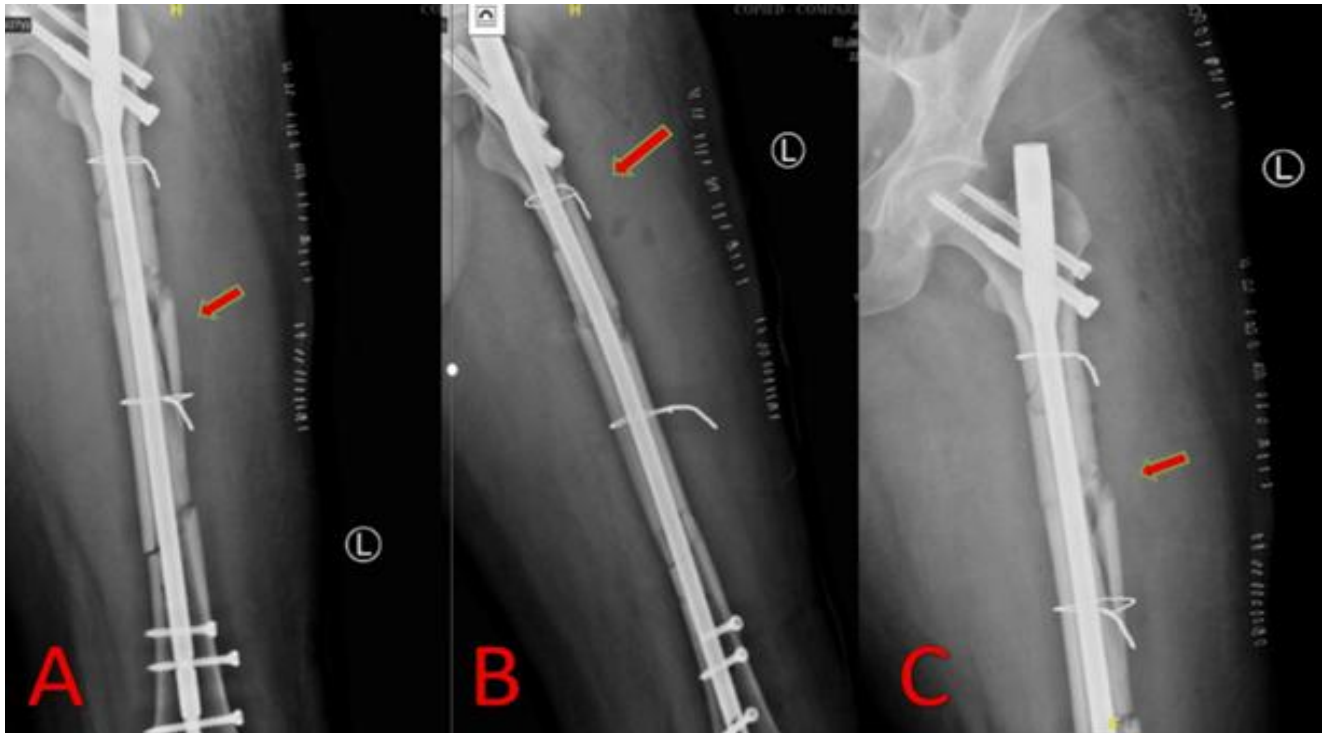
(A-C): Anteroposterior and lateral radiographs of the left femur at 12-month follow-up in case 1 showing a well-aligned and uniting subtrochanteric and segmental shaft fracture following intramedullary nailing. (A) Anteroposterior radiograph showing uniting left segmental shaft femur fracture. (B) Lateral radiograph showing uniting left subtrochanteric and segmental shaft femur fracture. (C) Anteroposterior radiograph showing uniting left subtrochanteric and segmental shaft femur fracture.
